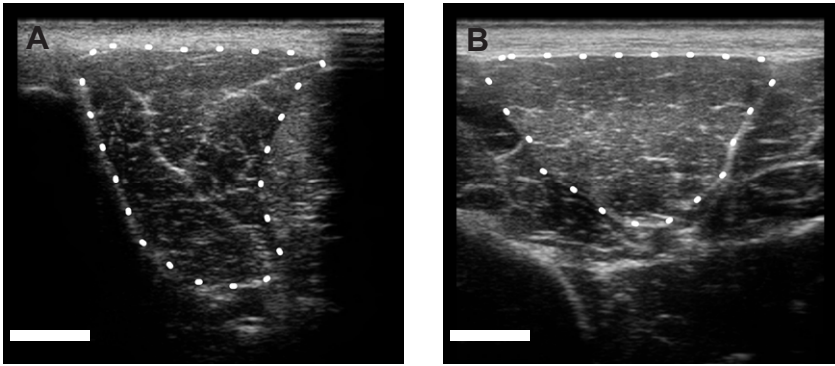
Ultrasound cross-sectional images of (A) the cranial tibial muscle and (B) the long digital extensor muscle of the brown bear, *Ursus arctos*. Each muscle is outlined with a dotted curve. Scale bars, 1 cm.
